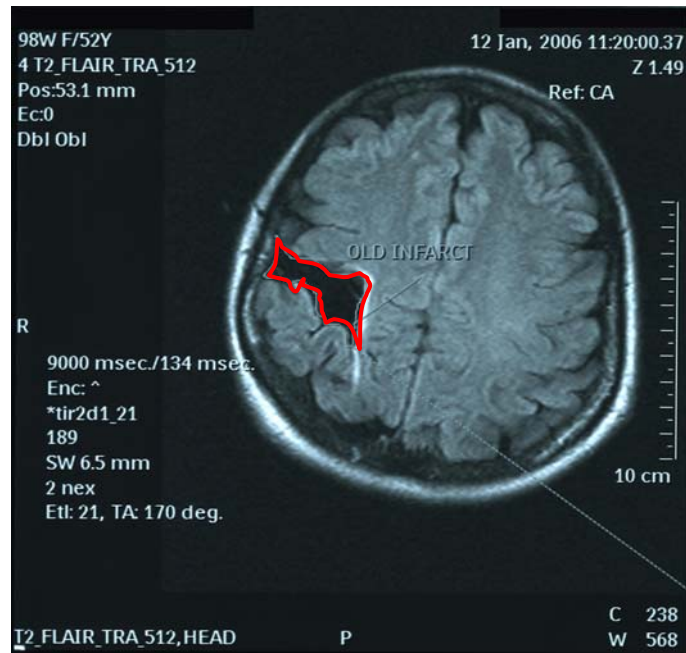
Old infarcts appear as black densities on an MRI
